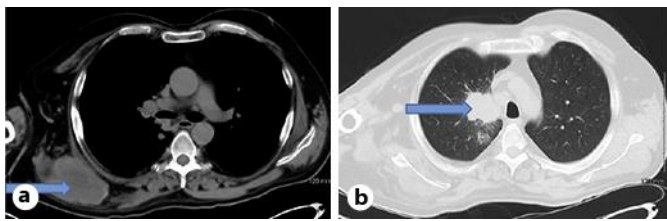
a CT of the chest showing ST mass with lytic destruction of the inferior margin of the right scapula. b CT of the chest showing right upper lobe lung mass.
